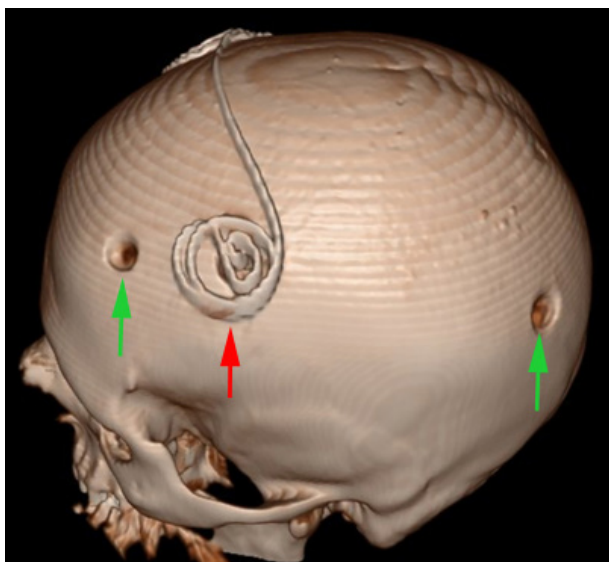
3D reconstruction of the postoperative CT image. Burr holes used to evacuate the hematoma are marked with green arrows, while the lead is marked by a red arrow.
